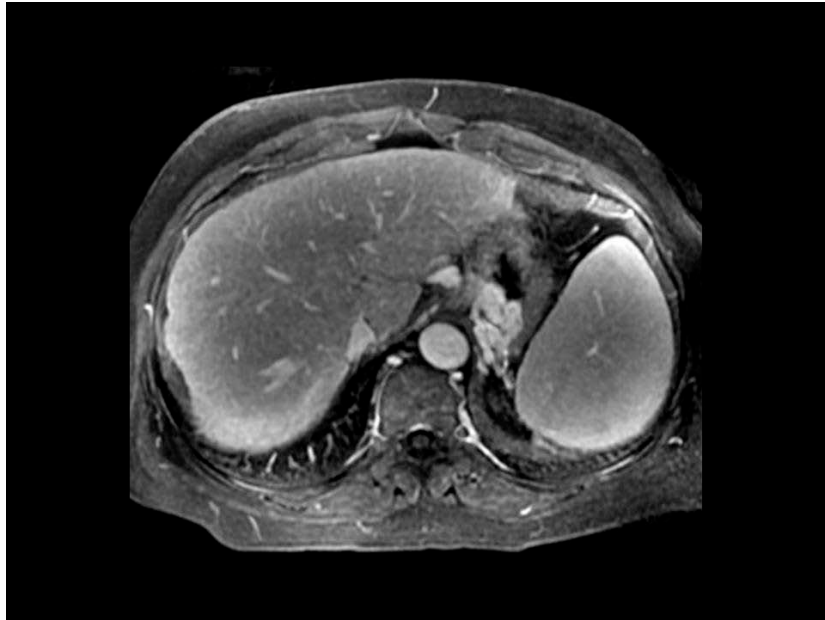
Postcontrast T1 weighted MRI abdomen shows varices in the fundus of the stomach.
